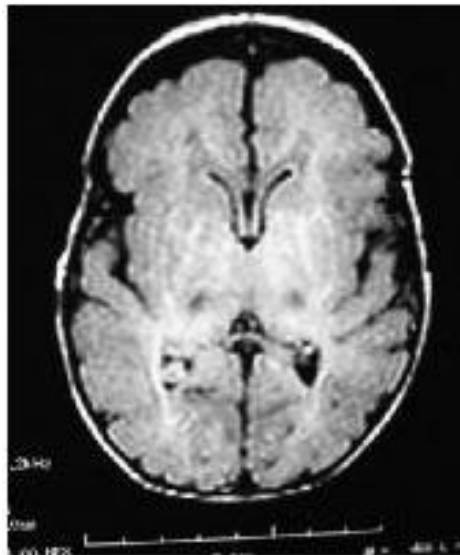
Magnetic Resonance Image (MRI) of a 9-day-old girl who was born at full term and had a perinatal hypoxic-ischemic event
